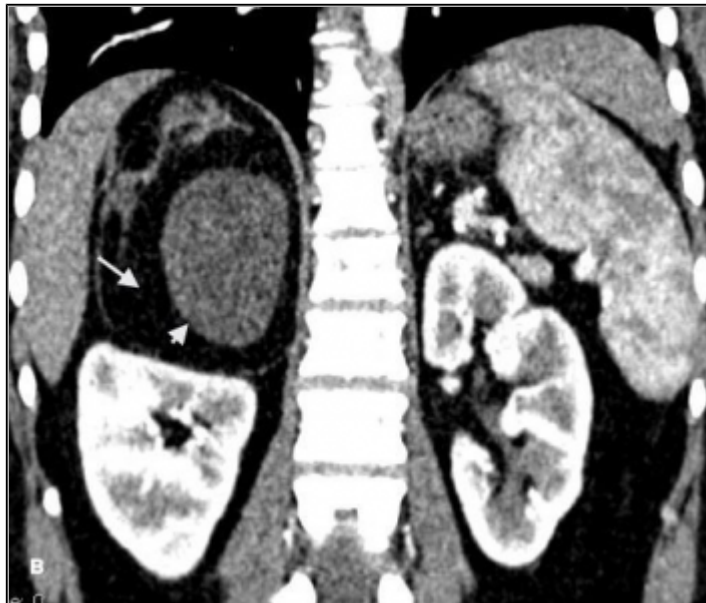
Abdominal CT with IV contrast reconstructed in coronal & sagittal planes.
